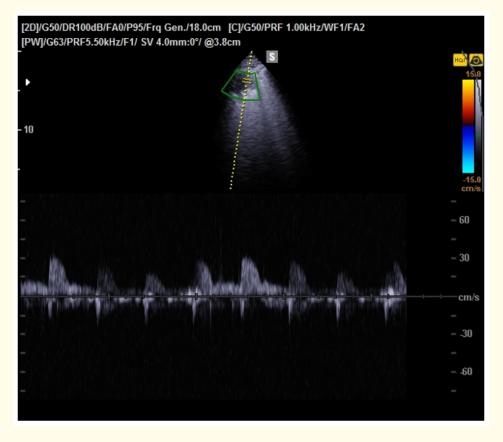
Clear spectral Doppler of the round subpleural consolidation with low resistance pulmonary arterial flow with peak systolic velocity 30 cm/sec, and end diastolic velocity 10 cm/sec.
